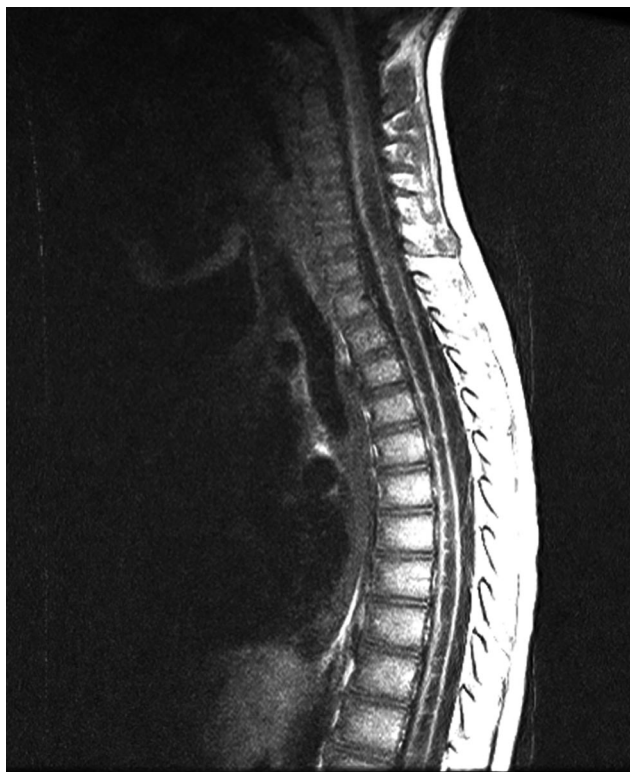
Pre-posterior fossa decompression sagittal T1-weighted MRI scan demonstrating a syringobulbia and dorso-lumbar syringomyelia.
